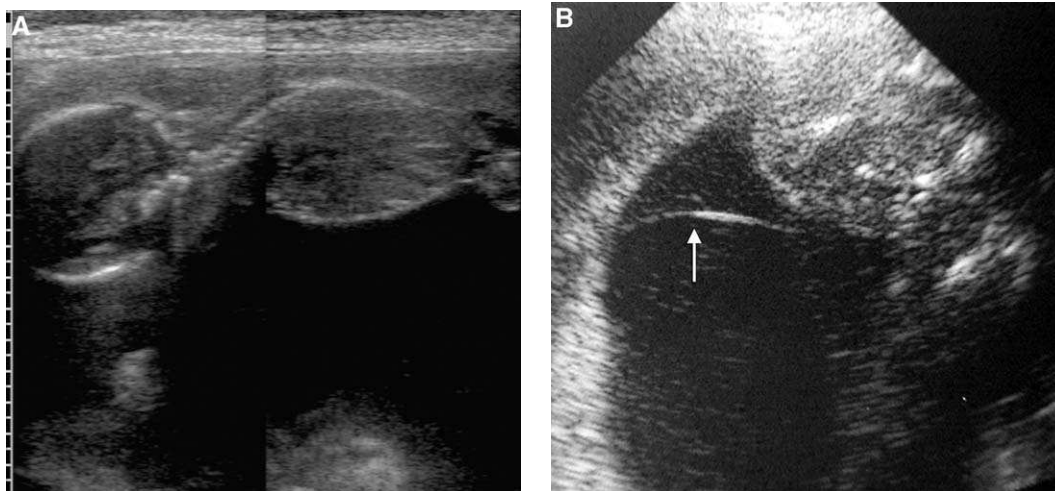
(A) The donor twin in this case of twin-twin transfusion syndrome is “stuck” within an anhydramniotic sac, closely adherent to the anterior uterine wall. (B) Careful sonographic evaluation along the margins of the stuck donor twin reveals a thin intertwin membrane (*arrow*) in this monochorionic diamniotic gestation.
